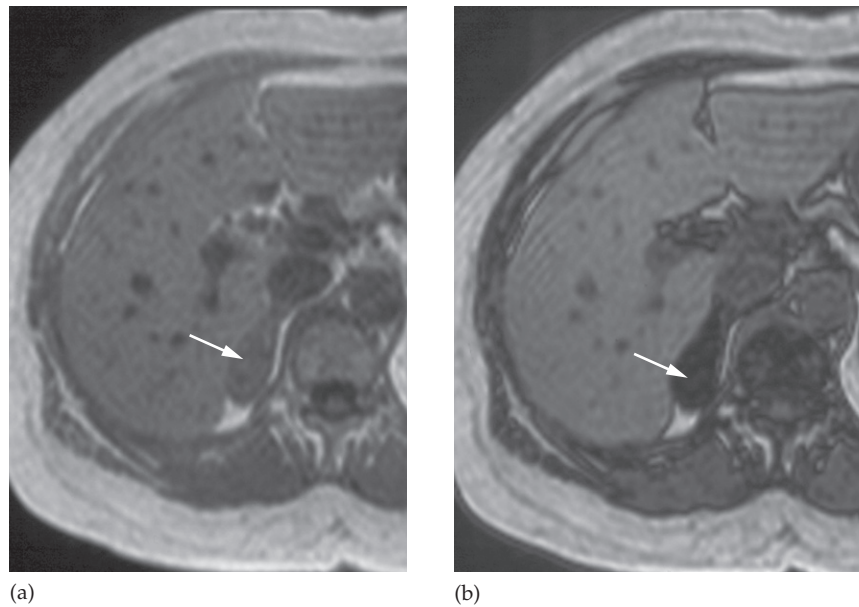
Adrenal cortical adenoma shown by chemical shift MRI. (a) An adrenal mass is demonstrated on the 'in-phase' image (arrow). (b) There is a marked drop in the signal intensity of the adrenal mass on the 'out-of-phase' image, confirming a benign cortical adenoma (arrow).
